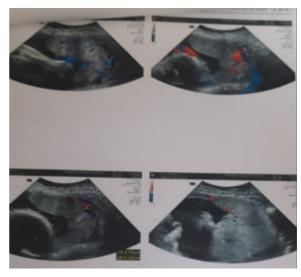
Colour Doppler images of placenta previa.
